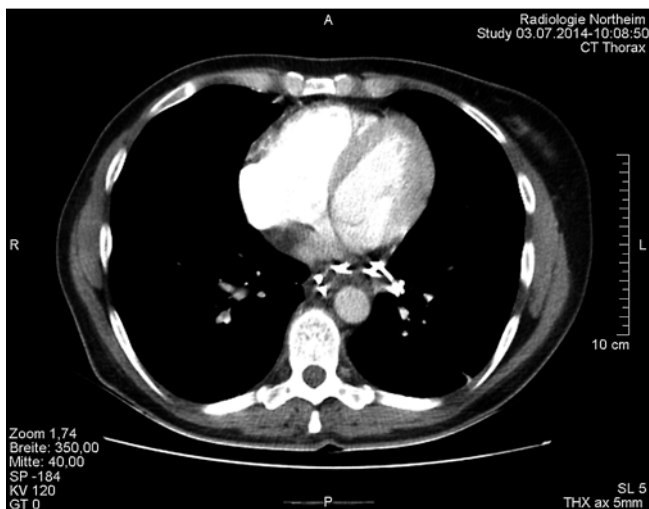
Corresponding to Fig. 5, the CT scan 11 days after drainage showed that the cyst had almost completely disappeared.
